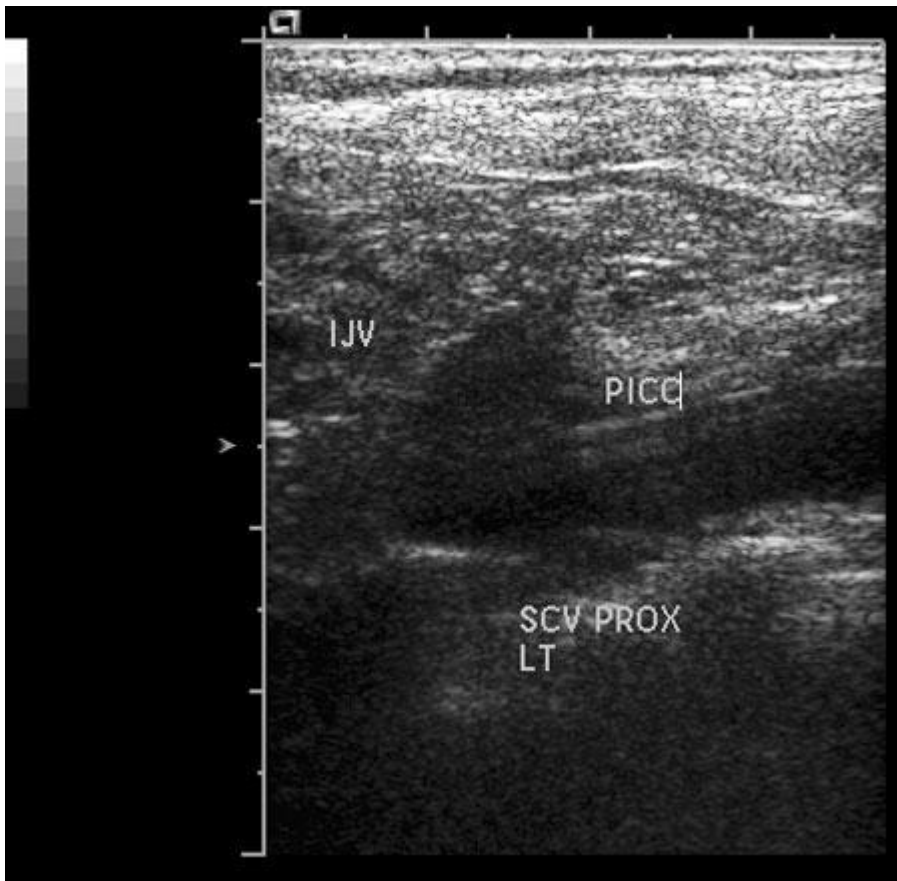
A PICC will typically be placed in the cephalic, basilic or brachial veins. Placement in the basilic and cephalic veins is possible by palpation, specifically at the elbow. Ultrasound guidance is used for accurate placement. This is considered essential if the brachial vein is used since the brachial veins are in close proximity to the brachial artery. On this image, the upper portion of a PICC is seen as it transits towards a more central location and is shown at the level of the brachiocephalic vein.
